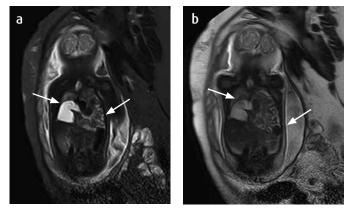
MRI a) Sagittal STIR; b) with coronal T2 information. Patient 20.6 weeks gestation. Thoracic anomaly due to decreased bilateral lung volume with greater left compromise is observed. Right of 2.56 cm × 1.70 cm × 2.23 cm and volume of 4.86 cm3; Left of 1.60 cm × 1.40 cm × 1.30 cm and volume of 1.51 cm3. Additionally, dextrocardia is seen. A left posterolateral diaphragmatic hernia defect is visualized with protrusion of segments II and III of the liver, gastric chamber and intestinal loops.
